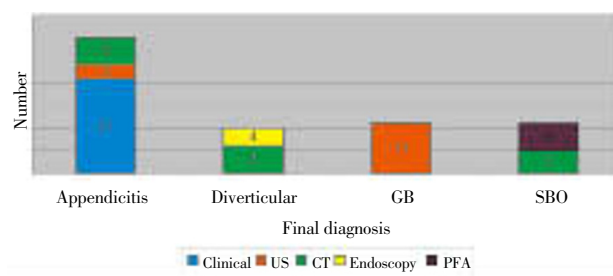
The rate or frequency of various tools or modalities in confirming the final diagnosis of acute surgical abdomen. *GB = Gallbladder disease; SBO = Subacute bowel obstruction; US = Ultrasound abdomen; CT = CT abdomen/pelvis; PFA = Plain film of abdomen.
